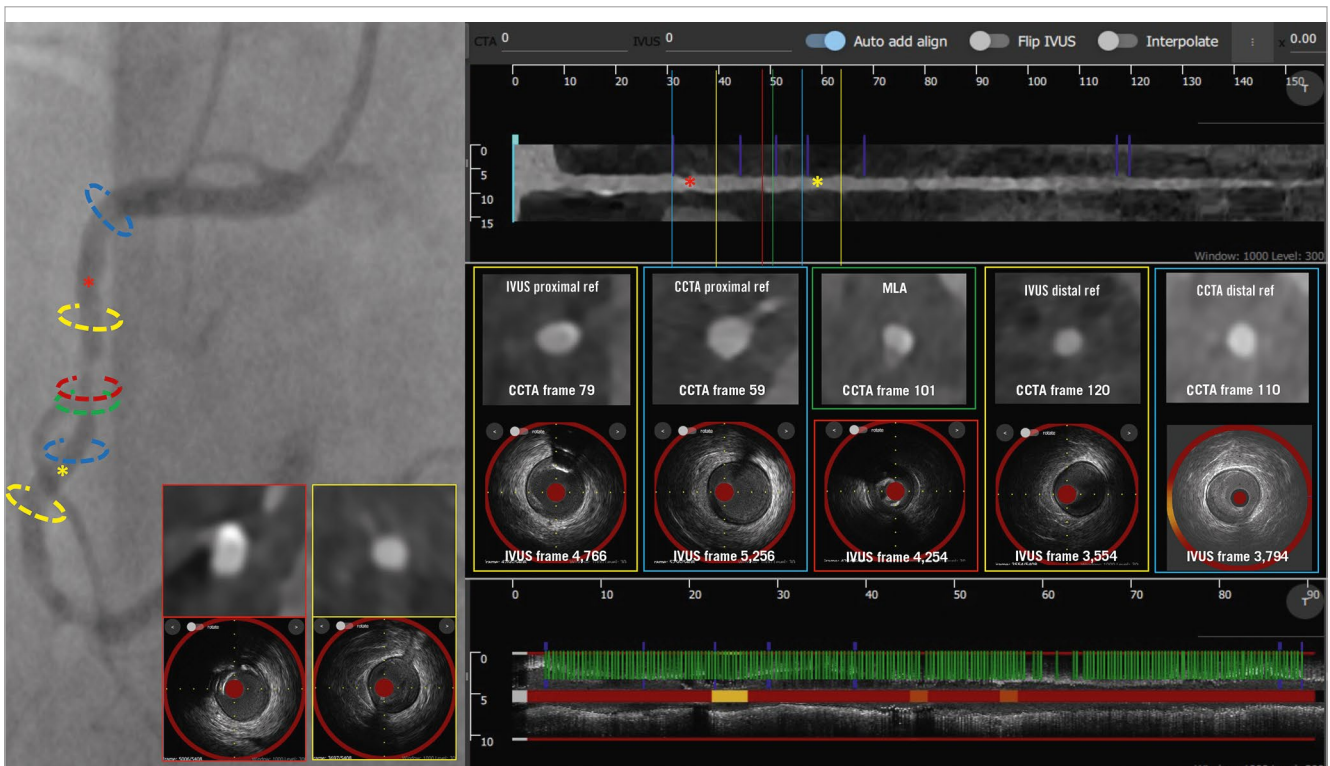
Case example of NIRS-IVUS- and CCTA-guided right coronary artery PCI. The treated lesion is shown on the coronary angiogram, along with CCTA and NIRS-IVUS longitudinal images. The location of the MLA on NIRS-IVUS (red) and CCTA (green) are different. The NIRS-IVUS proximal and distal reference areas are marked in yellow, while the CCTA proximal and distal reference areas are marked in blue. There was a significant difference in the landing zone estimations between NIRS-IVUS and CCTA; CCTA overestimated the PB in the calcific segment proximal to the lesion, while distally it missed a fibrotic plaque compared to NIRS-IVUS. CaBI: calcific burden index; CCTA: coronary computed tomography angiography; IVUS: intravascular ultrasound; MLA: minimum lumen area; NIRS-IVUS: near-infrared spectroscopy-intravascular ultrasound; PB: plaque burden; PCI: percutaneous coronary intervention
